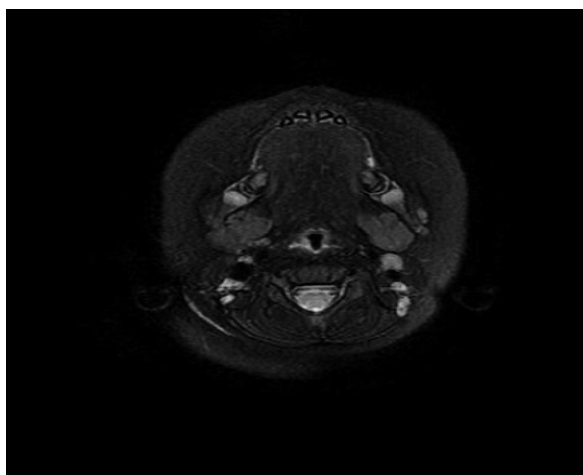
Brain MRI after 1 year of treatment shows regression of hemangioma
